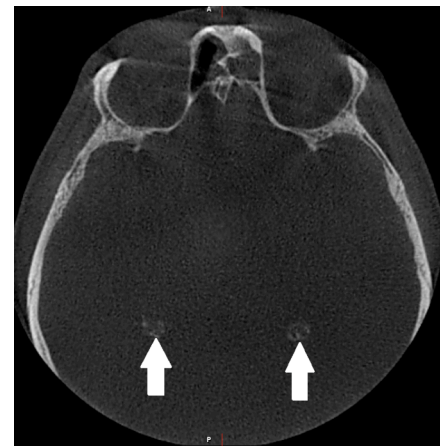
Axial CBCT image of bilateral choroid plexus calcifications (arrows).
